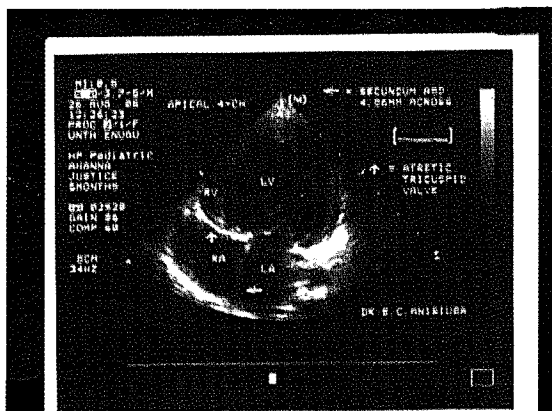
2-D Echo (Apical 4-Chamber view) Showing Atretic Tricuspid Valve (?), Hypoplastic Right Ventricle (RV) and Secundum ASD (?)
